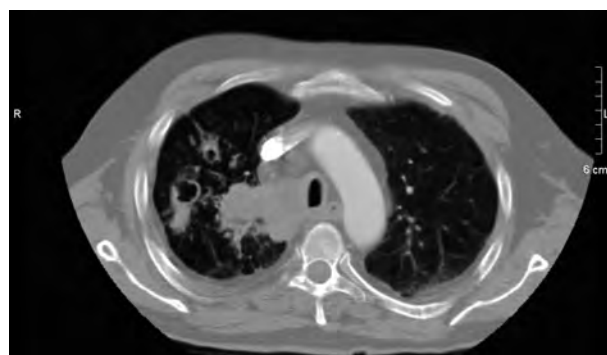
Chest computed tomography showing a cavitary lesion in the right upper lobe and right parahilar adenopathies.
